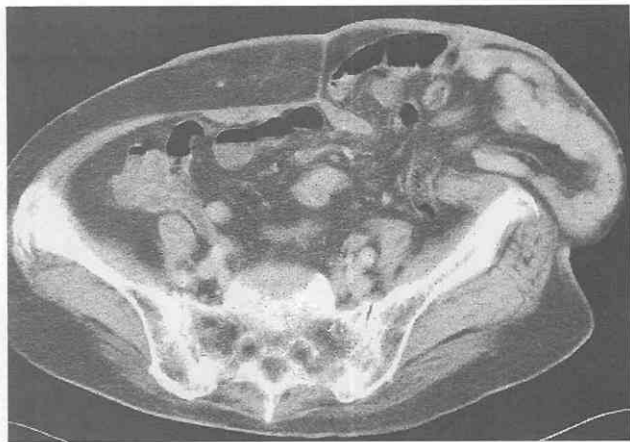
Spigelian hernia. CT scan shows herniation of the mesentery and small-bowel loop into the sac.
